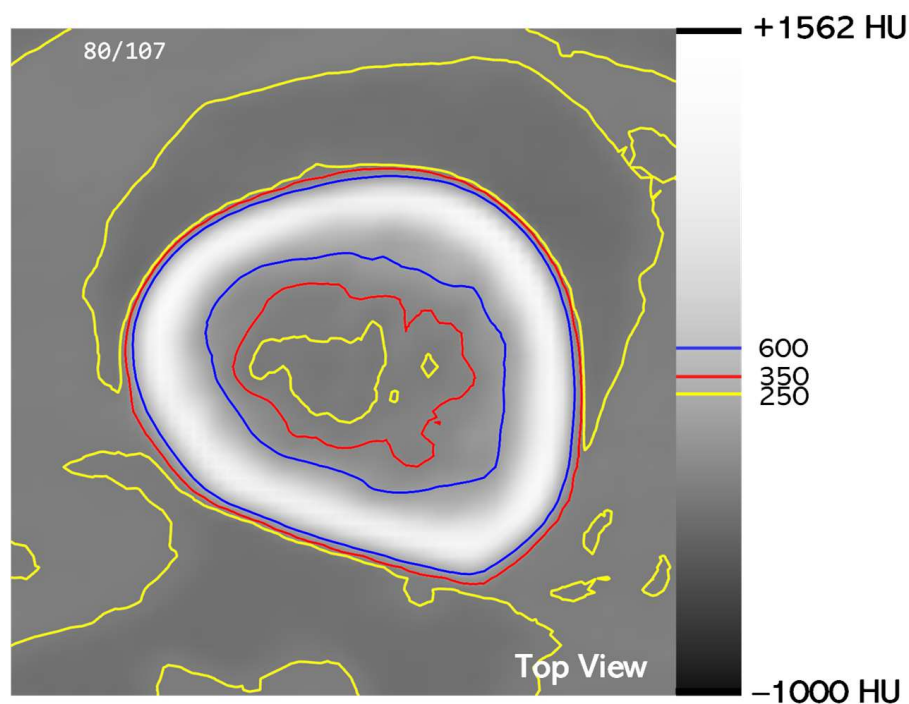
Visualization of the isocurves for the isovalues at HU = 250 (yellow), 350 (red), and 600 (blue) on top of the corresponding CT slice in grayscale colors.
